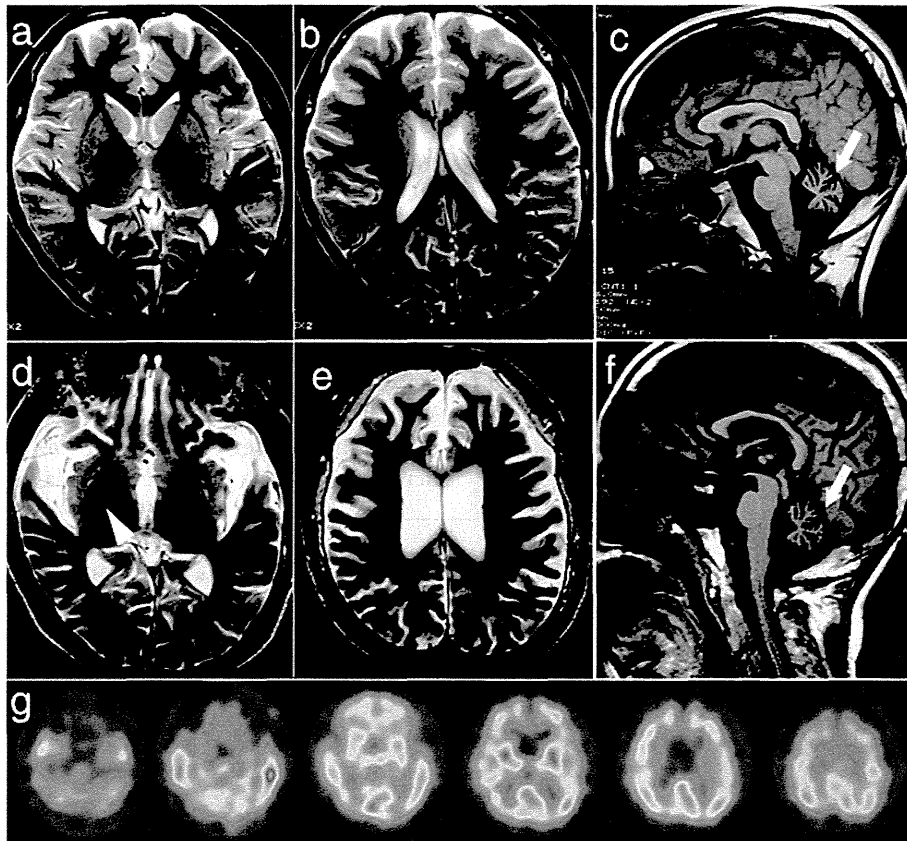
Magnetic resonance imaging (MRI) and Tc99m-ECD-single-photon emission computed tomography (SPECT) of the patient. a-c MRI at age 12. There was mild atrophy of the frontal cortex and slightly low intensity in the globus pallidus on T2-weighted images (T2WI) (a, b). The sagittal section of the T1WI exhibited cerebellar atrophy (arrow) (c). d-f MRI at age 18. Low signal intensity in the globus pallidus (arrowhead) and atrophy of the temporal lobes was clear on the T2WI (d). The frontal lobes showed severe atrophy (e). The sagittal section of the T1WI exhibited severe cerebellar atrophy (arrow) and thinness of the corpus callosum (f). An ECD-SPECT, at age 18, revealed hypoperfusion of the frontotemporal lobes and cerebellum (g).
